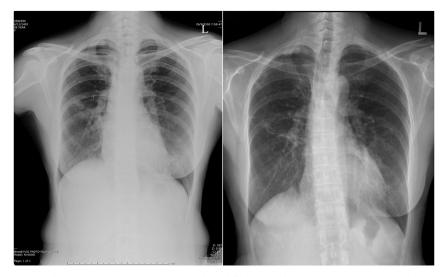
Chest radiography at the time of diagnosis shows opacities at the right middle lung field. (Left figure) Chest radiography after treatment completion shows residual bronchiectasis in the right middle lung field. (Right figure).
